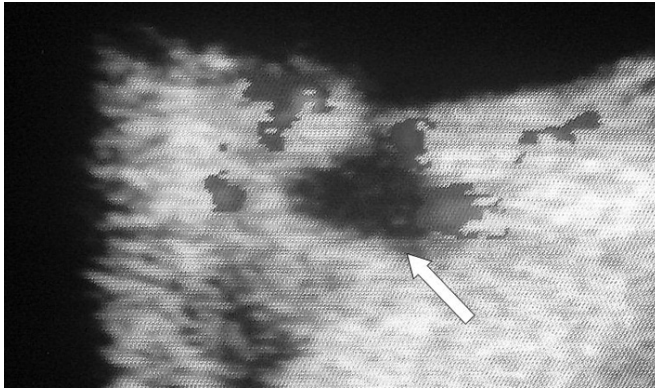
B-scan ultrasonography shows minimal excavation of the optic disc (arrow).
